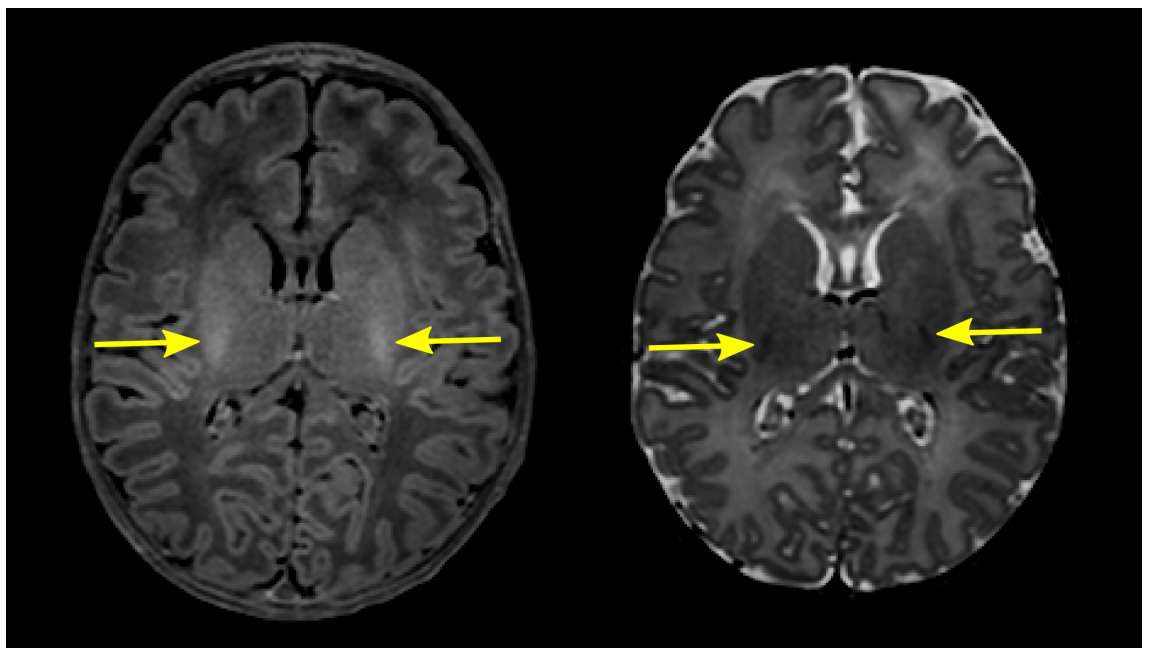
T1-weighted (left) and T2-weighted (right) images of an infant born at 39.6 weeks GA and imaged after 2 days. The yellow arrows indicate the posterior limb of the internal capsule, which is myelinated at term and is seen as high signal intensity and low signal intensity on the T1- and T2-weighted images, respectively.
